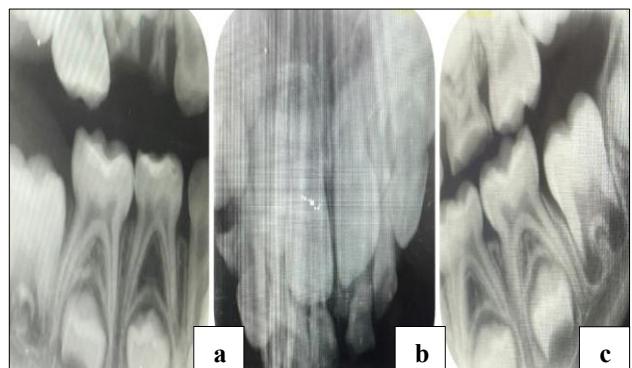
(a-c): Pre-operative intra-oral radiographs: Arrows highlighting areas of dental caries.
